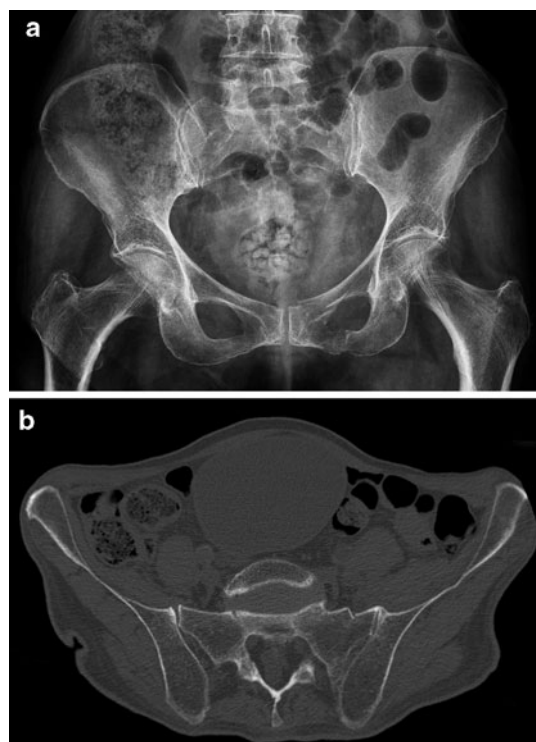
Fractures of the pubic rami on the left side in an 87-year-old female after a simple fall (a). CT shows an associated ipsilateral sacral compression fracture (b)
